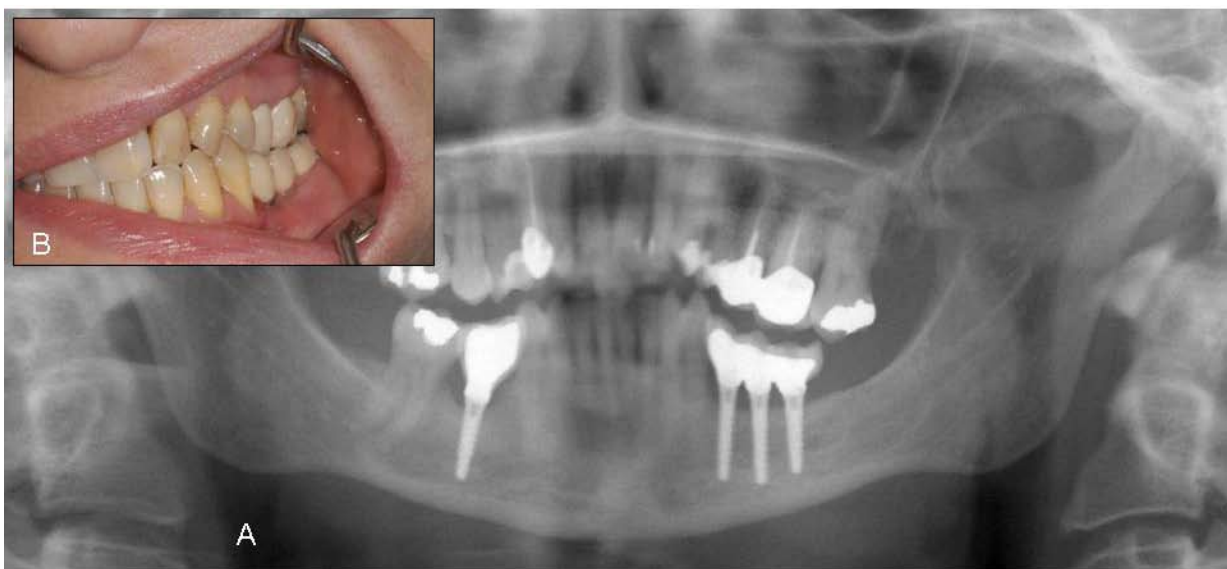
A. Panoramic X-ray view of the final result.
